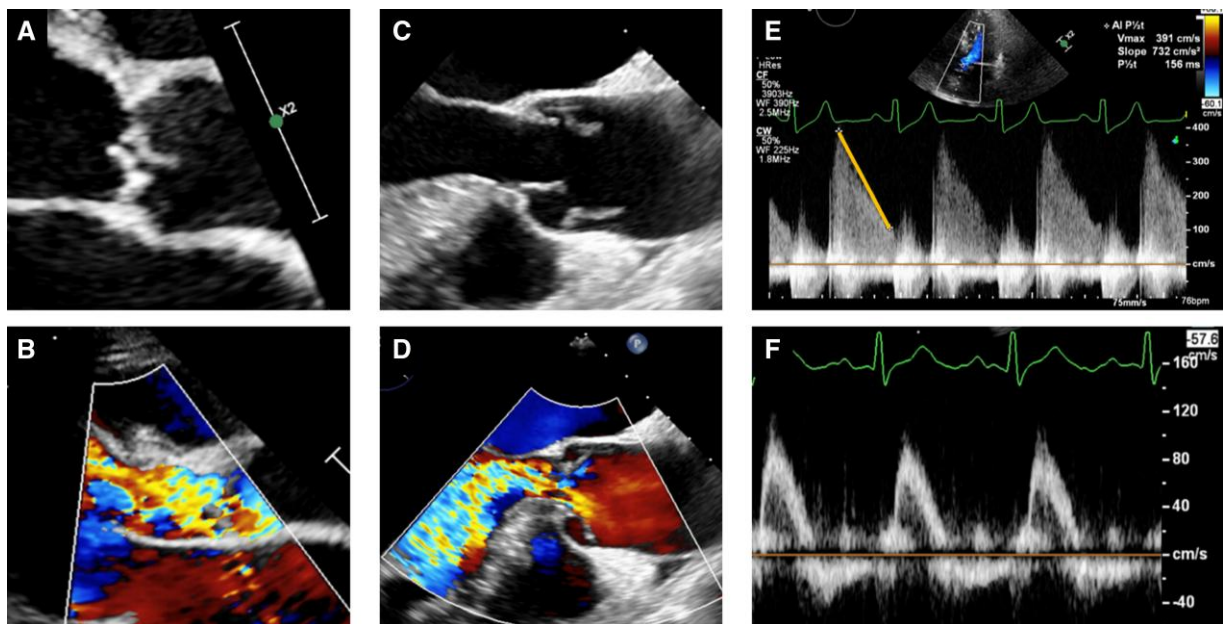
Echocardiographic findings in acute aortic regurgitation. Two-dimensional and colour Doppler imaging of a flail aortic valve leaflet (A, B) and Type A dissection with intimal flap prolapse (C, D). Continuous-wave Doppler demonstrating a short pressure half-time with low end-diastolic velocity (E) and pulsed-wave Doppler showing diastolic flow reversal in the abdominal aorta (G).
